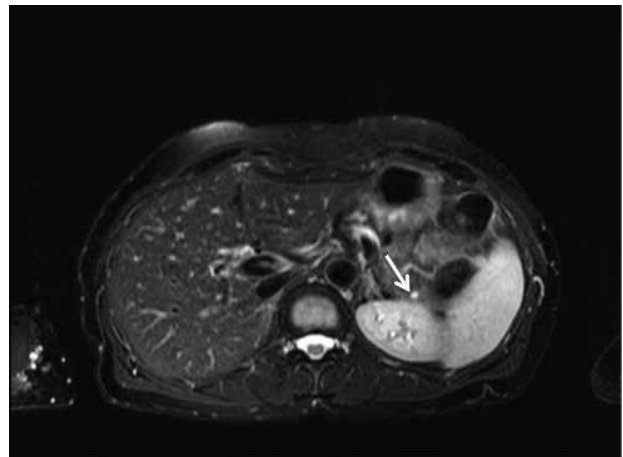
Magnetic resonance imaging of the abdomen showing a 6-mm, contrast-enhanced lesion in the tail of the pancreas (arrow)
